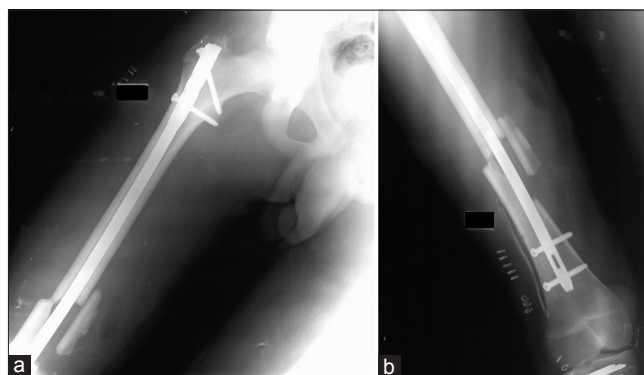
(a and b) Postoperative anteroposterior radiograph shows reduction and intramedullary fixation of right femur
